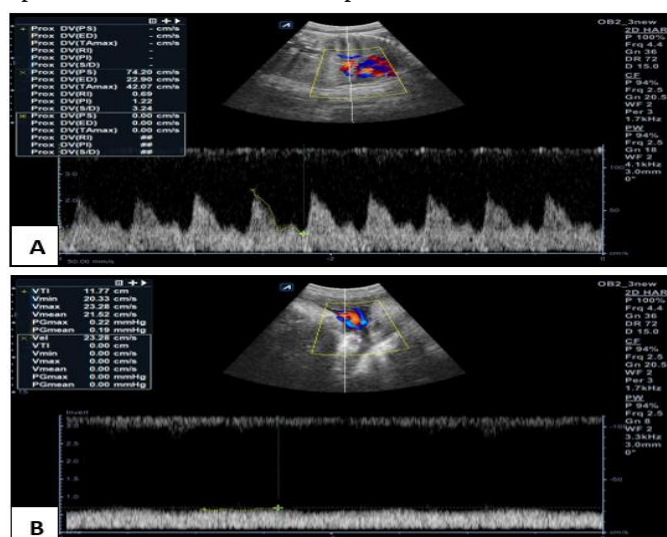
Doppler findings in a 27-year-old multigravida at 36 weeks of gestation with fetal growth restriction (estimated fetal weight: 1900 g) and no identifiable risk factors. (A) Ductus venosus Doppler showing a mildly increased pulsatility index. (B) Umbilical vein Doppler demonstrating normal monophasic flow. Cesarean delivery was performed because of a non-reassuring fetal heart rate, and the neonate required a brief NICU admission.
